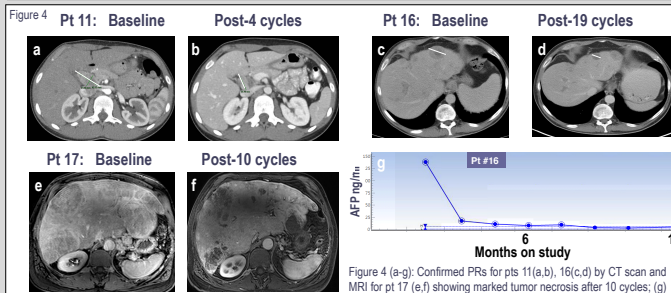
(a-g): Confirmed PRs for pts 11(a,b), 16(c,d) by CT scan and MRI for pt 17 (e,f) showing marked tumor necrosis after 10 cycles. (g) aAFP for pt 16
